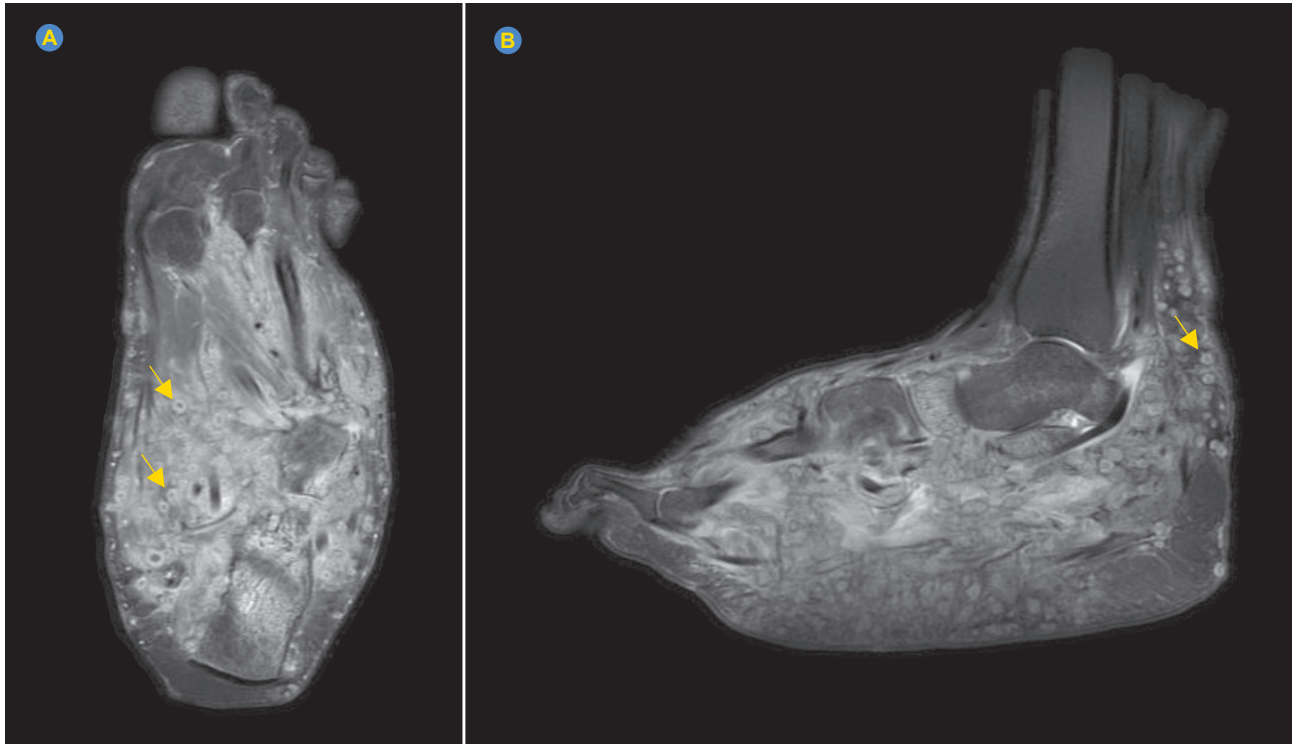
MRI revealing nodular lesions, with 'dot-in-circle' sign (arrows), involving bone, muscles and subcutaneous tissue of the left foot
